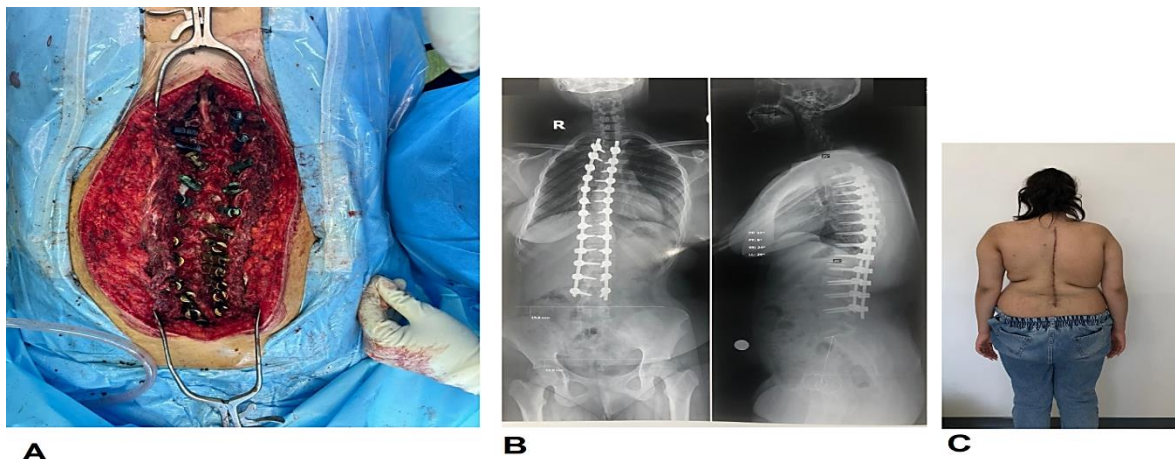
A) Intraoperative photography of surgical site; B) Post-operative radiographies; C) Post-operative photograph of the patient
